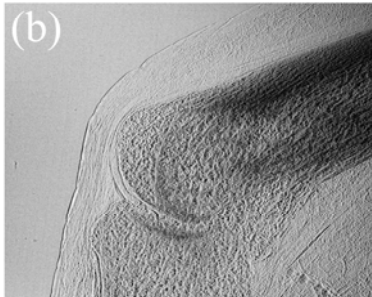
X-ray images of the PIP joint taken at BL14C1 as a detailed experiment.
